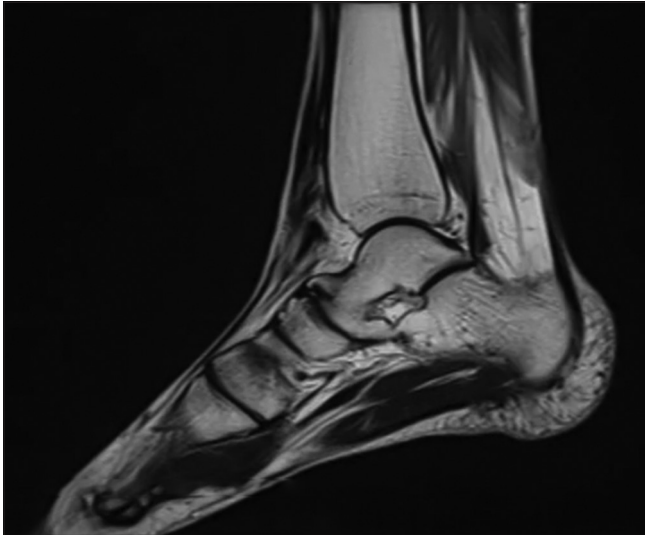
Magnetic resonance images of a patient (a) axial and (b) sagittal T1-weighted images depicting marrow continuity (arrows) between the talus and calcaneum suggesting a solid osseous fusion involving medial facet of the subtalar joint. Also seen on the sagittal image is traction spur/enthesophyte (open arrow) arising from the dorsal head of the talus, also referred to as the “talar beak.” (c) Sagittal short-tau inversion recovery image showing irregularities and bone marrow edema (arrows) of opposing surfaces of talus and calcaneum at the posteriorly located facet of the subtalar joint with reduced joint space suggestive of subtalar arthritis.
